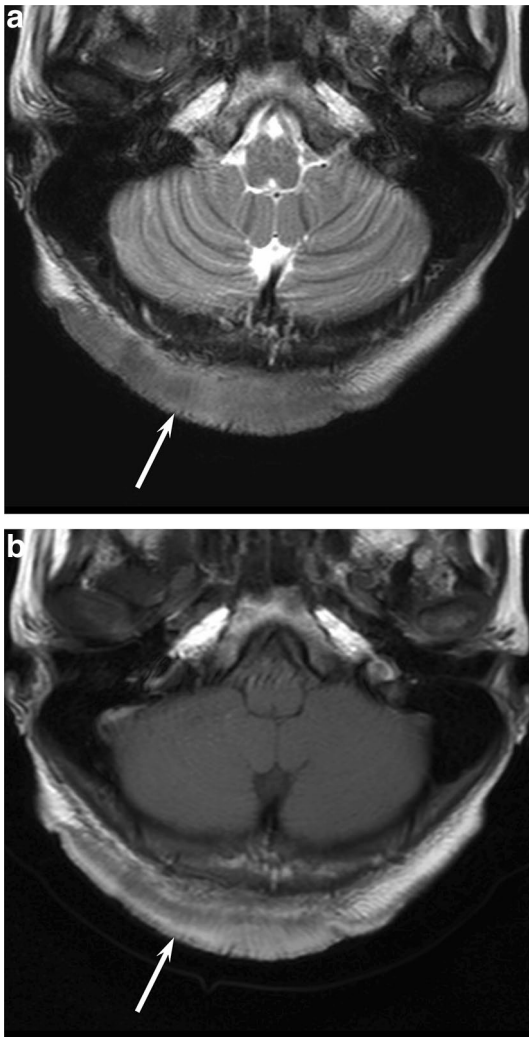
A 20-year-old woman with melanocytic nevi. a T2-weighted image shows an ill-demarcated, heterogeneously hypo- to hyperintense, subcutaneous lesion (arrow). b T1-weighted image shows heterogeneous iso- to hyperintensity (arrow)
